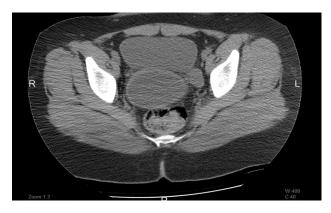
CT scan axial cuts shows hematocolpos.
